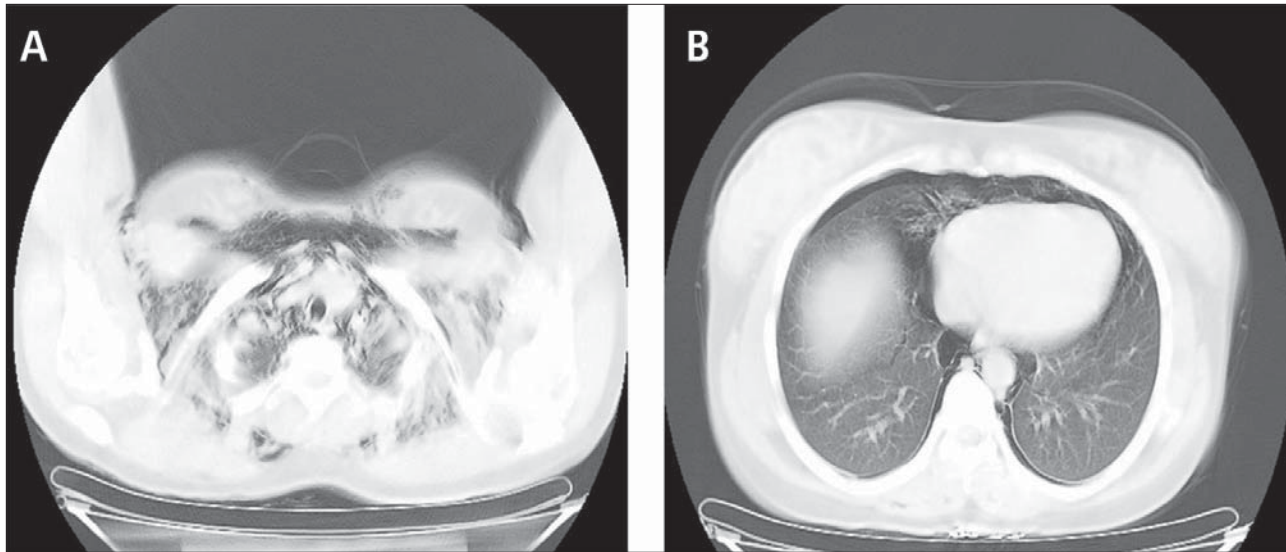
Thoracic CT image.
